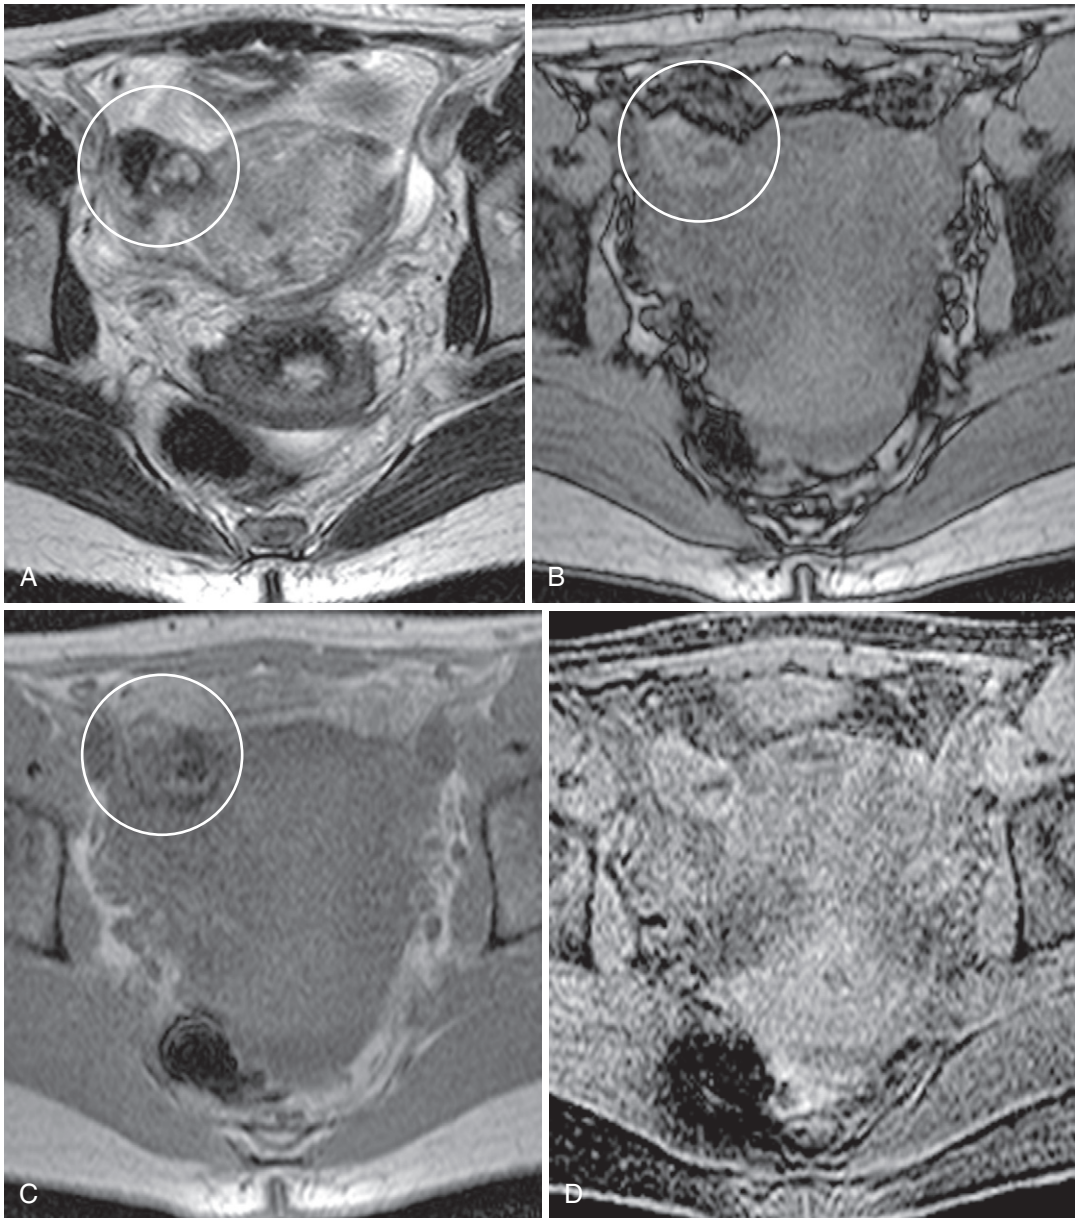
Ectopic pregnancy. Axial T2-weighted (A), T1-weighted out-of-phase (B) and T1-weighted in-phase (C) images. The right cornual region has a small complex cystic lesion (*circle*) with central fluid signal, a thin peripheral rim of hemorrhage, and an adjacent, lateral hypointense focus (presumably blood). Precontrast (D) and postcontrast (E and F) T1-weighted fat-suppressed images reveal enhancement around the lesion indicating inflammation (*arrow* in E and F). G, Corresponding CT image shows the right lower quadrant inflammation (*arrows*) adjacent to the lesion (*circle*). The α -fetoprotein measured approximately 35, and no intrauterine pregnancy was identified.
